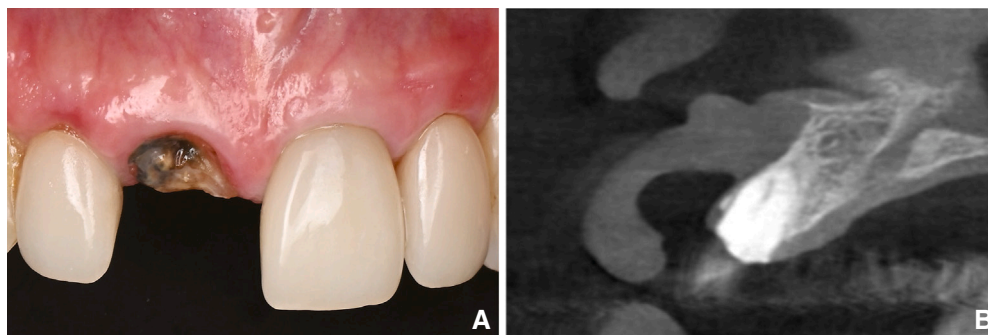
Preoperative condition. A, Frontal view of maxillary arch showing remaining root of maxillary right central incisor. B, Sagittal cross-sectional CBCT view of remaining root of maxillary right central incisor. CBCT, cone beam computed tomography.
